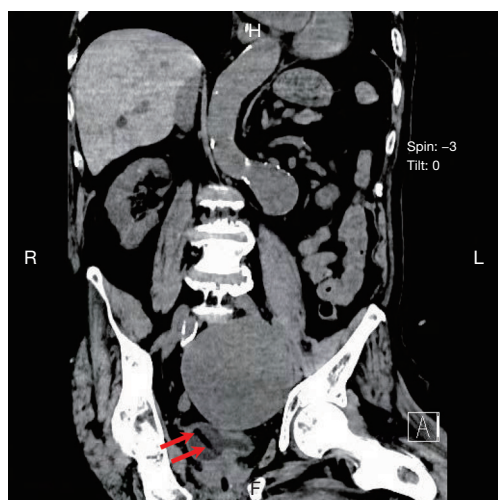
Abdominal computed tomography showed that the end of the urinary catheter (marked by the red arrows) was left in the bladder diverticulum.
